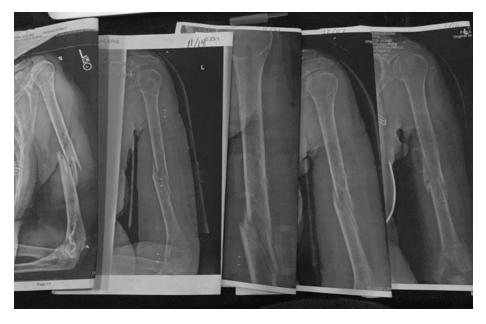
X-ray of bones over two months from break to healing.
